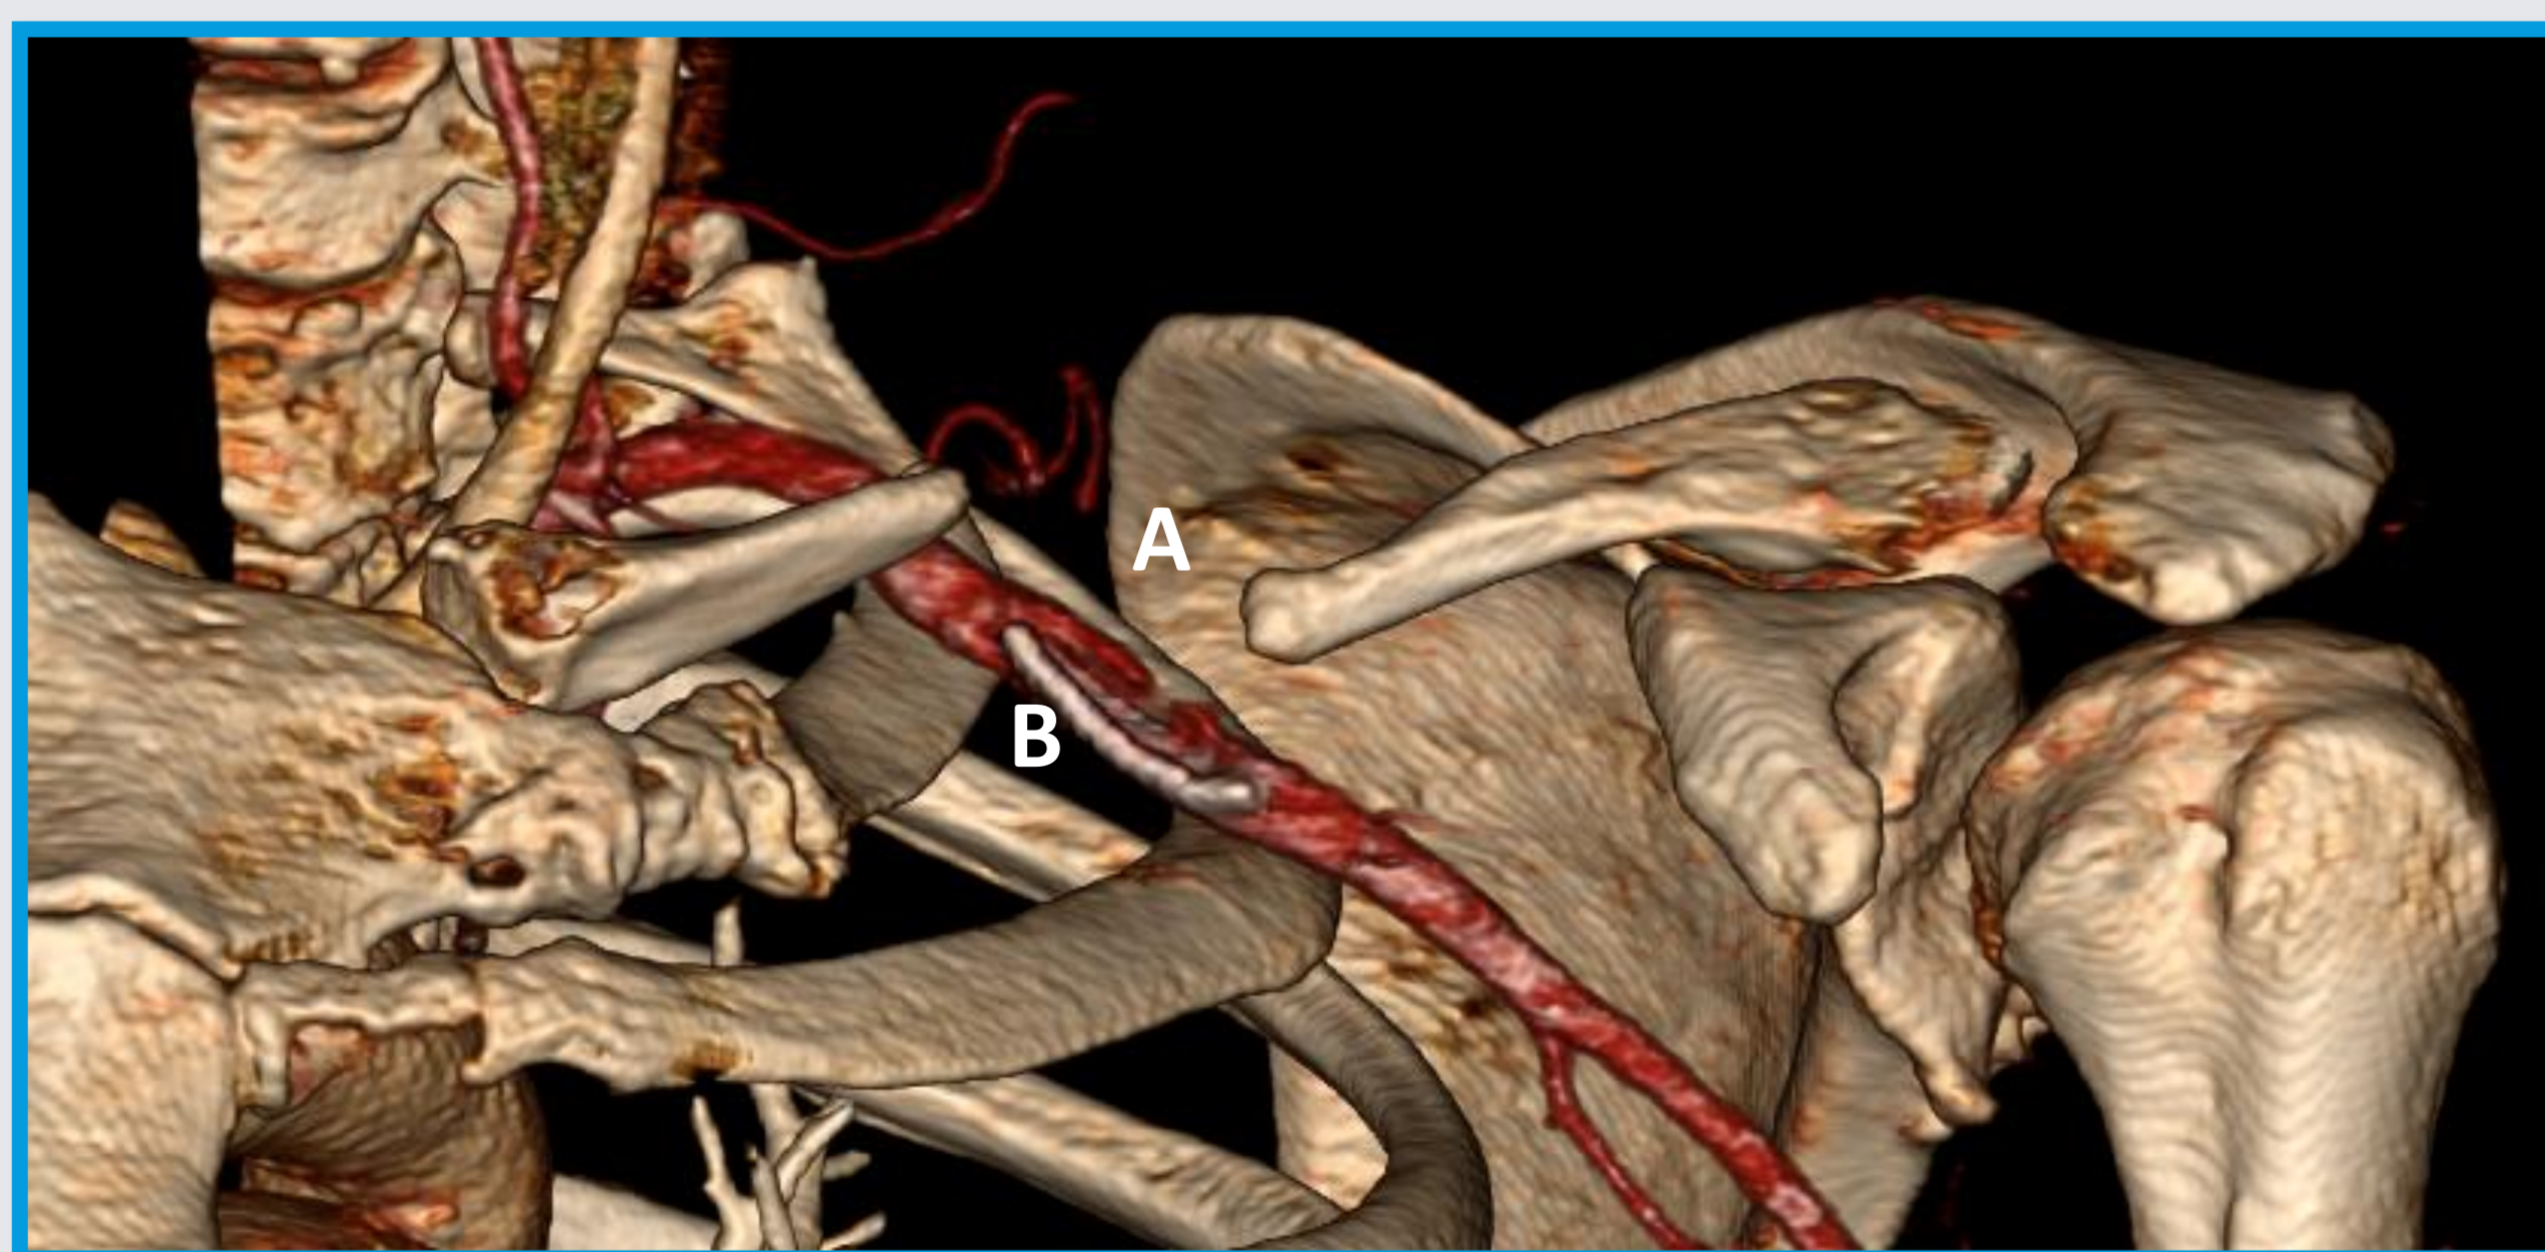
CT-scan of clavicular defect (A) and stent compression (B)
